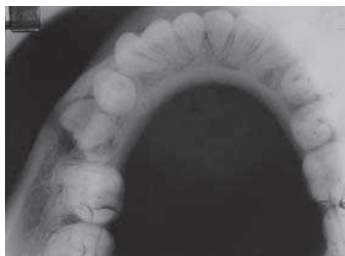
Occlusal radiograph showing a radiolucency extending into the buccal cortical bone in 75 region
